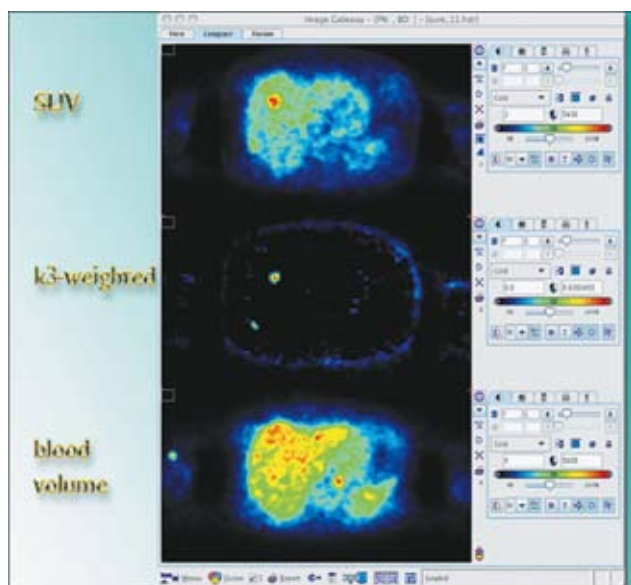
^{18}F -FDG-PET study, in a patient with liver metastases from colorectal carcinoma. for treatment monitoring following several therapies. Upper row: 55-60min SUV image of the liver demonstrating an enhanced uptake in one liver metastasis in the ventral part of the right liver lobe. Middle row: parametric image of the slope (related to phosphorylation) demonstrating two lesions with enhanced phosphorylation. Lower row: parametric image of the intercept (related to blood volume) showing an enhanced but homogenous blood volume distribution.
